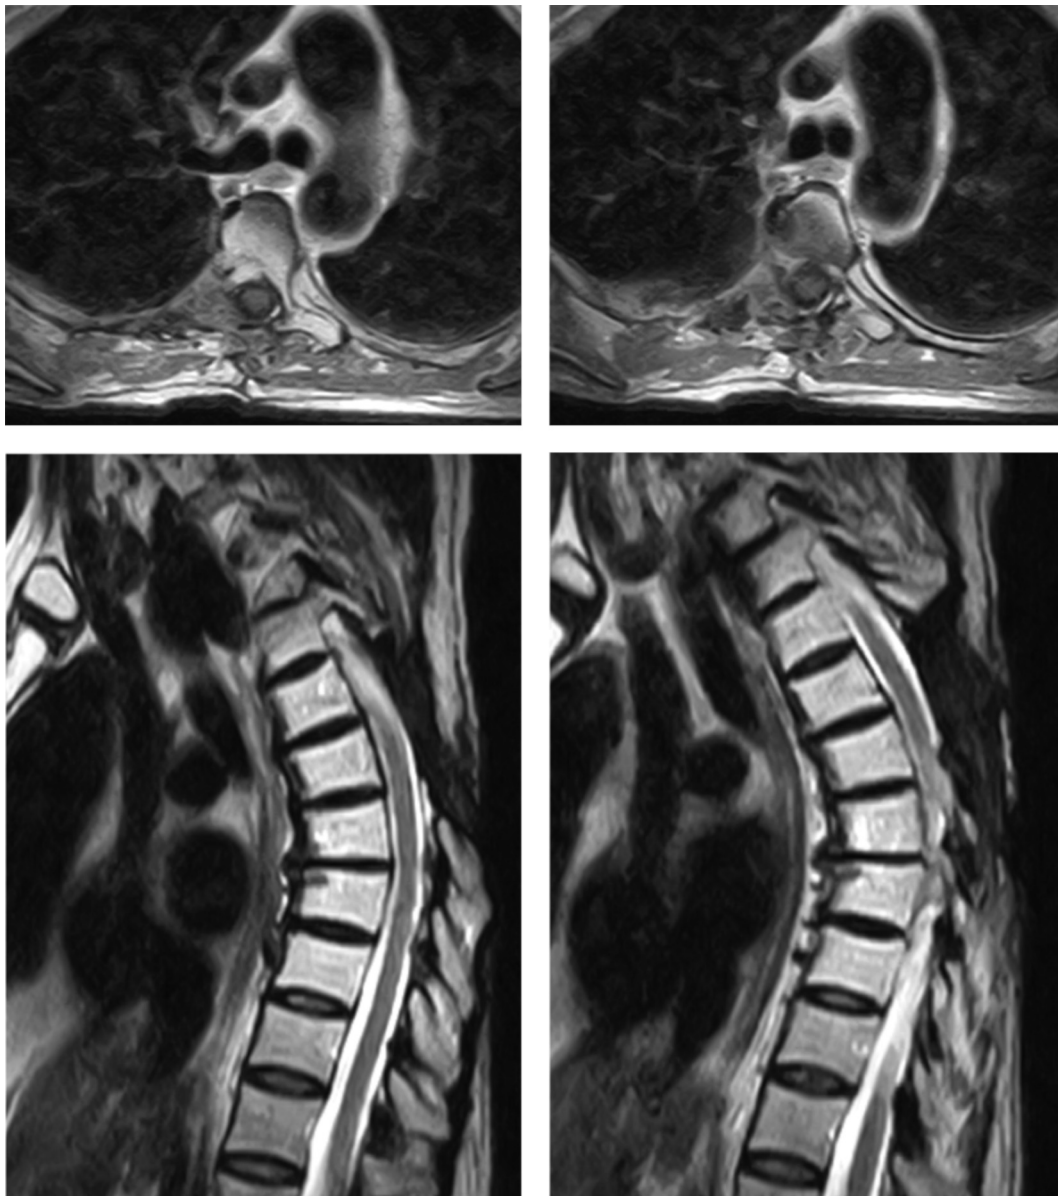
Postoperative follow-up MRI at 3 years.
